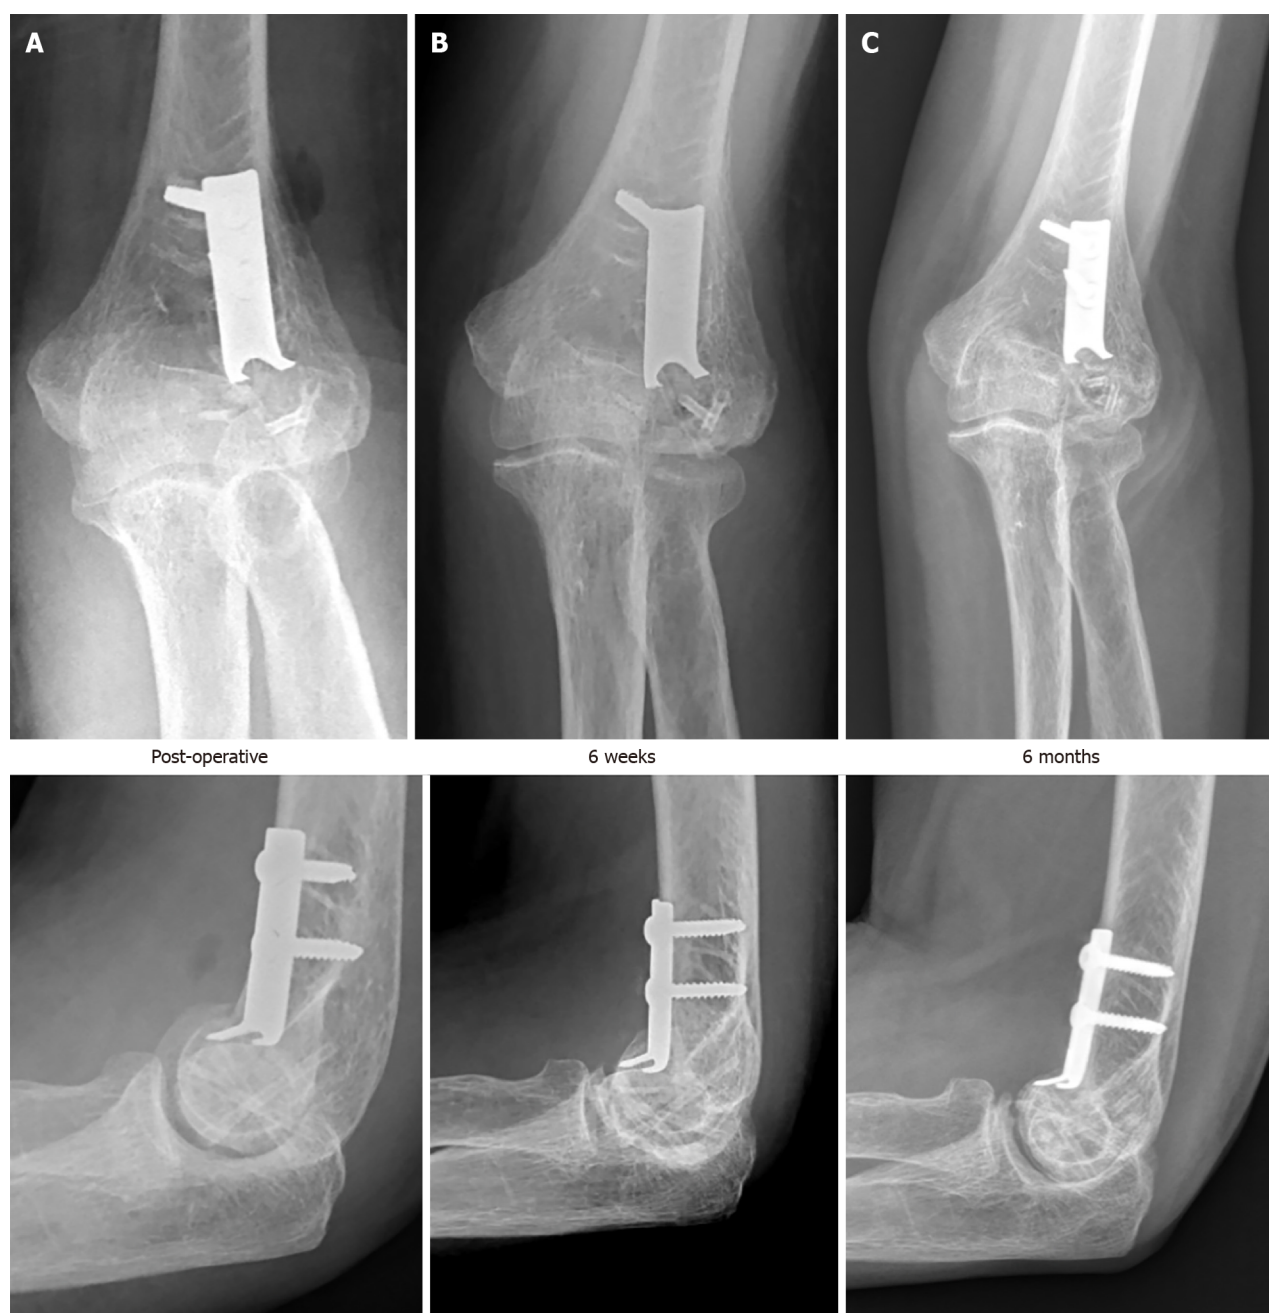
Post operative radiographs depicting progress. A-C: Radiographs immediately post op (A), at 6 wk (B) and at 6 months (C).
